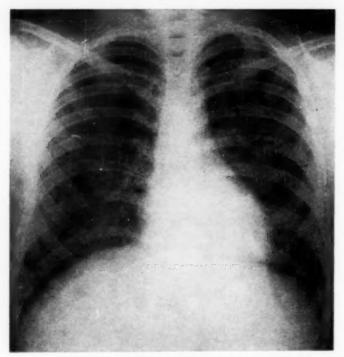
Case 8. Non-hospitalized patient with thin-walled cavity in left hilus, found on routine roentgenogram. Asymptomatic.
